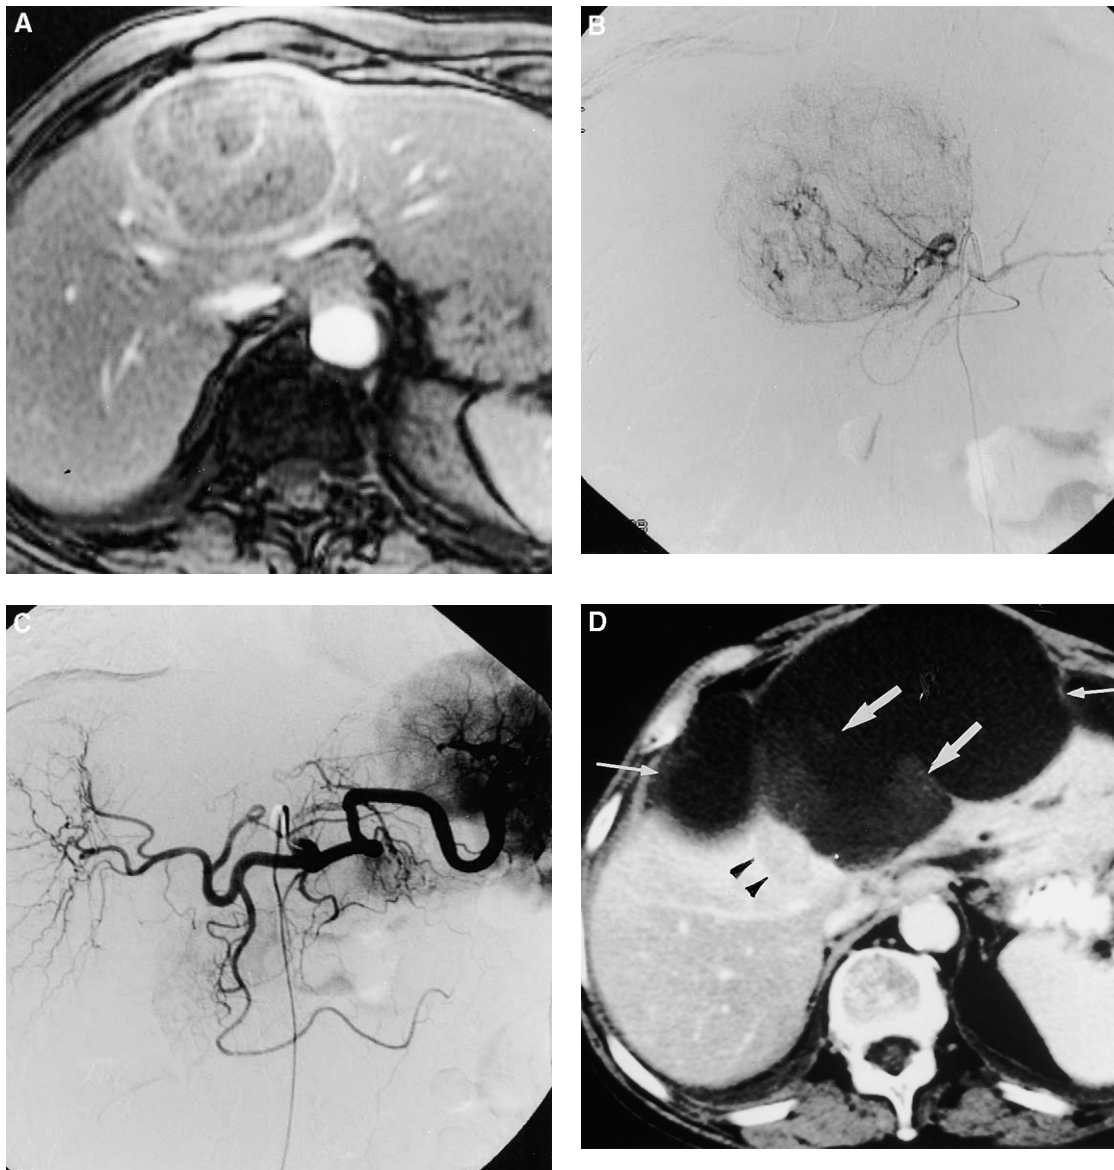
A, Dynamic T1-weighted MRI from a 76-year-old woman (patient 3) shows a large heterogeneous mass with an enhancing capsule in segment IV of the liver. B, This patient had cirrhosis related to long-term methotrexate treatment for psoriasis. She underwent chemoembolization with selective catheterization of the left hepatic artery. C, Control celiac arteriogram after chemoembolization demonstrates abrogation of the vascularity of the mass. This patient underwent cryoablation of the tumor 4 weeks later. D, Dynamic contrast-enhanced CT of the liver 14 months after cryosurgery shows infarcted tissue (*wide arrow*), adjacent fluid collections (*narrow arrows*), and residual tumor (*arrowheads*).
